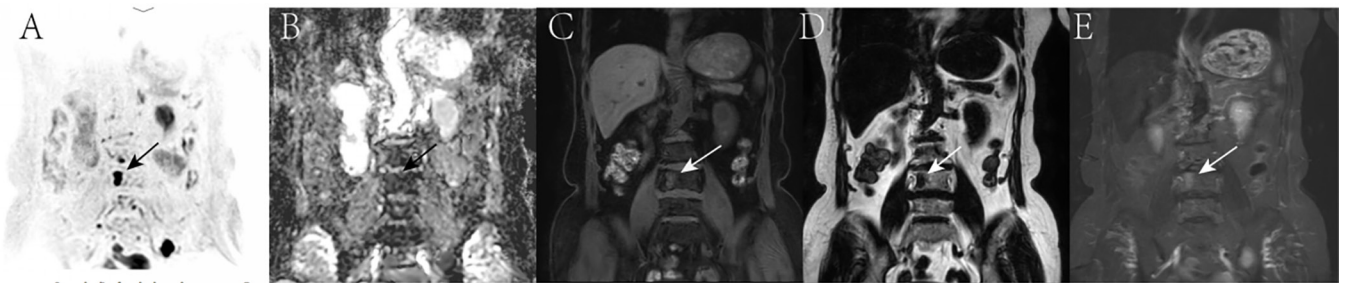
A focal lesion was clearly shown on all sequences. The focal lesion shows hyperintensity on coronal DWI image (A), isointensity on ADC image (B), T2-STIR image (C), hypointensity on fat phase image (D), and water phase image (E). DWI, diffusion-weighted imaging; STIR, short-time inversion recovery; ADC, apparent diffusion coefficient.
